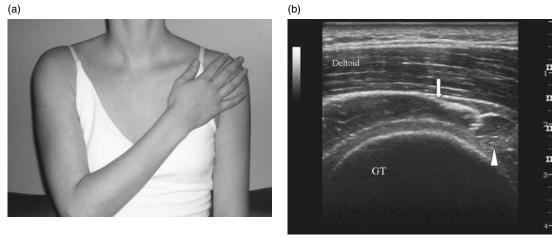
(a) Patient position for evaluation of the infraspinatus and teres minor tendons, posterior labrum, and spinoglenoid notch and (b) transverse ultrasound image of the junction of the inferior border infraspinatus (arrow) and superior border teres minor (arrowhead) muscles. GT, greater tuberosity.
